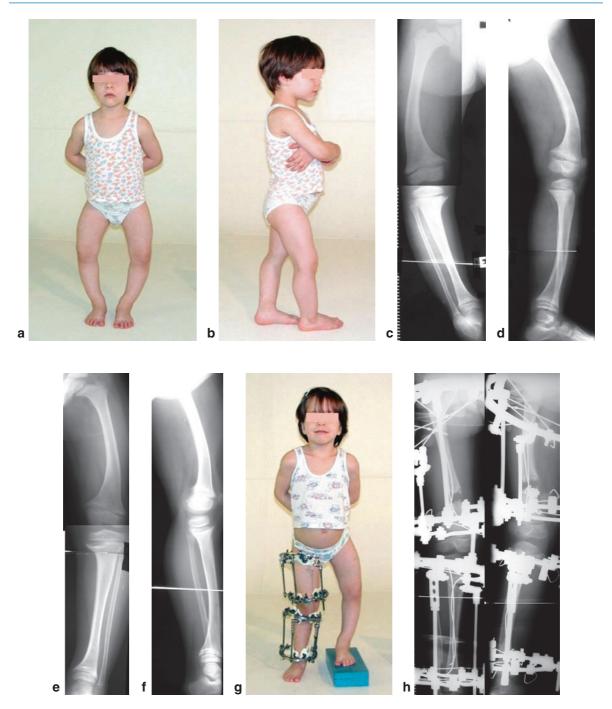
A 5-year-old girl with hypophosphatemic rickets before surgery. Clinical appearance (a, b). AP and lateral views, *right side* (c, d), *left side* (e, f). Ilizarov fixator in place for multisegmental fixation of the *right lower limb*: clinical appearance (g), X-rays (h)
